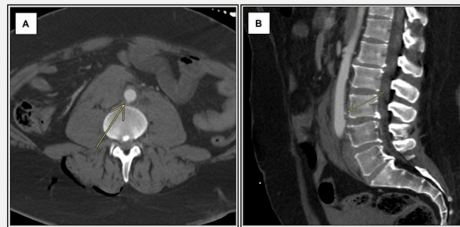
Preoperative computed tomography angiography demonstrating distal abdominal aortic PSA. A. Axial CTA of the abdomen showing focal posterior disruption of the distal infrarenal abdominal aorta (arrow) with a contained PSA and associated retroperitoneal hematoma. B. Sagittal CTA reconstruction demonstrating the same distal aortic PSA at the level just superior to the aortic bifurcation (arrow).
